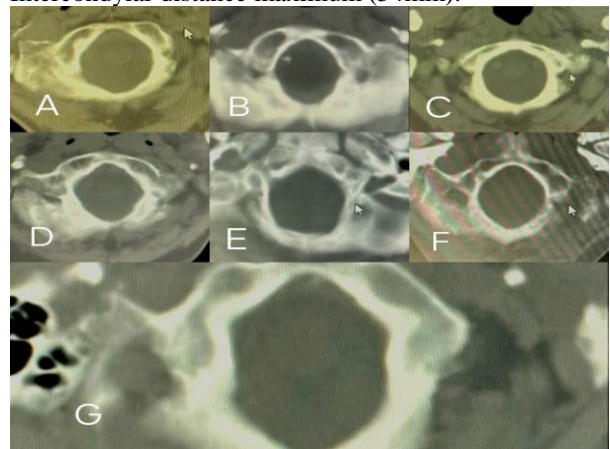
Pictures from CT scan showing various shapes of foramen magnum (A- Egg, B-Tetragonal, C-Round, D-Irregular, E-Pentagonal, F-Oval, G-Hexagonal).
